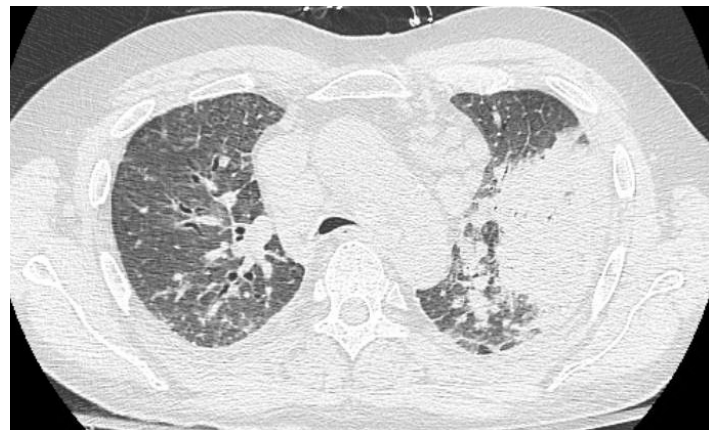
Bilateral lung opacities with associated lymphadenopathy seen on chest CT
